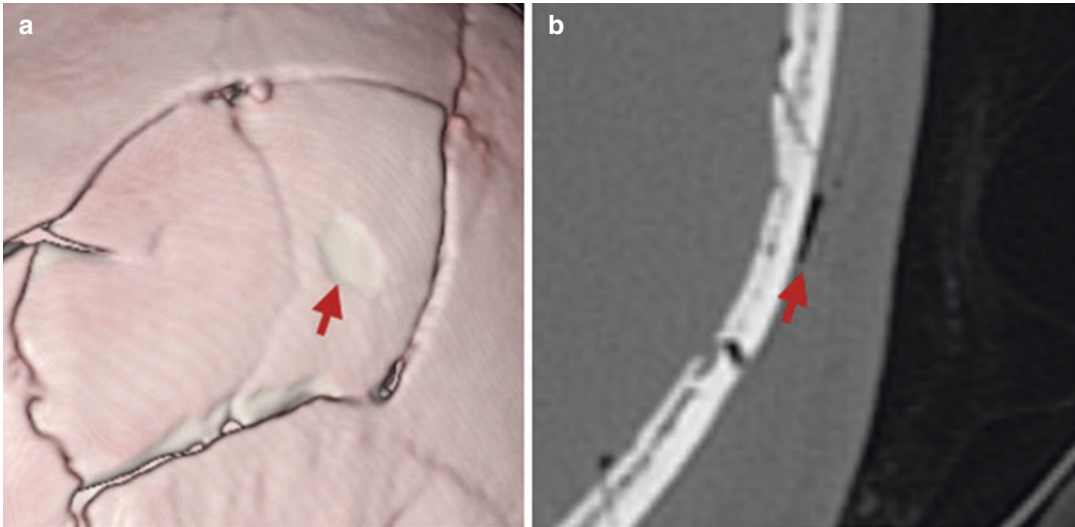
Three-dimensional image of the skull (a) suggesting a patterned bony defect indicating a depression (arrow). However, the original axial computed tomography image (b) shows no bone fracture and subcutaneous gas
